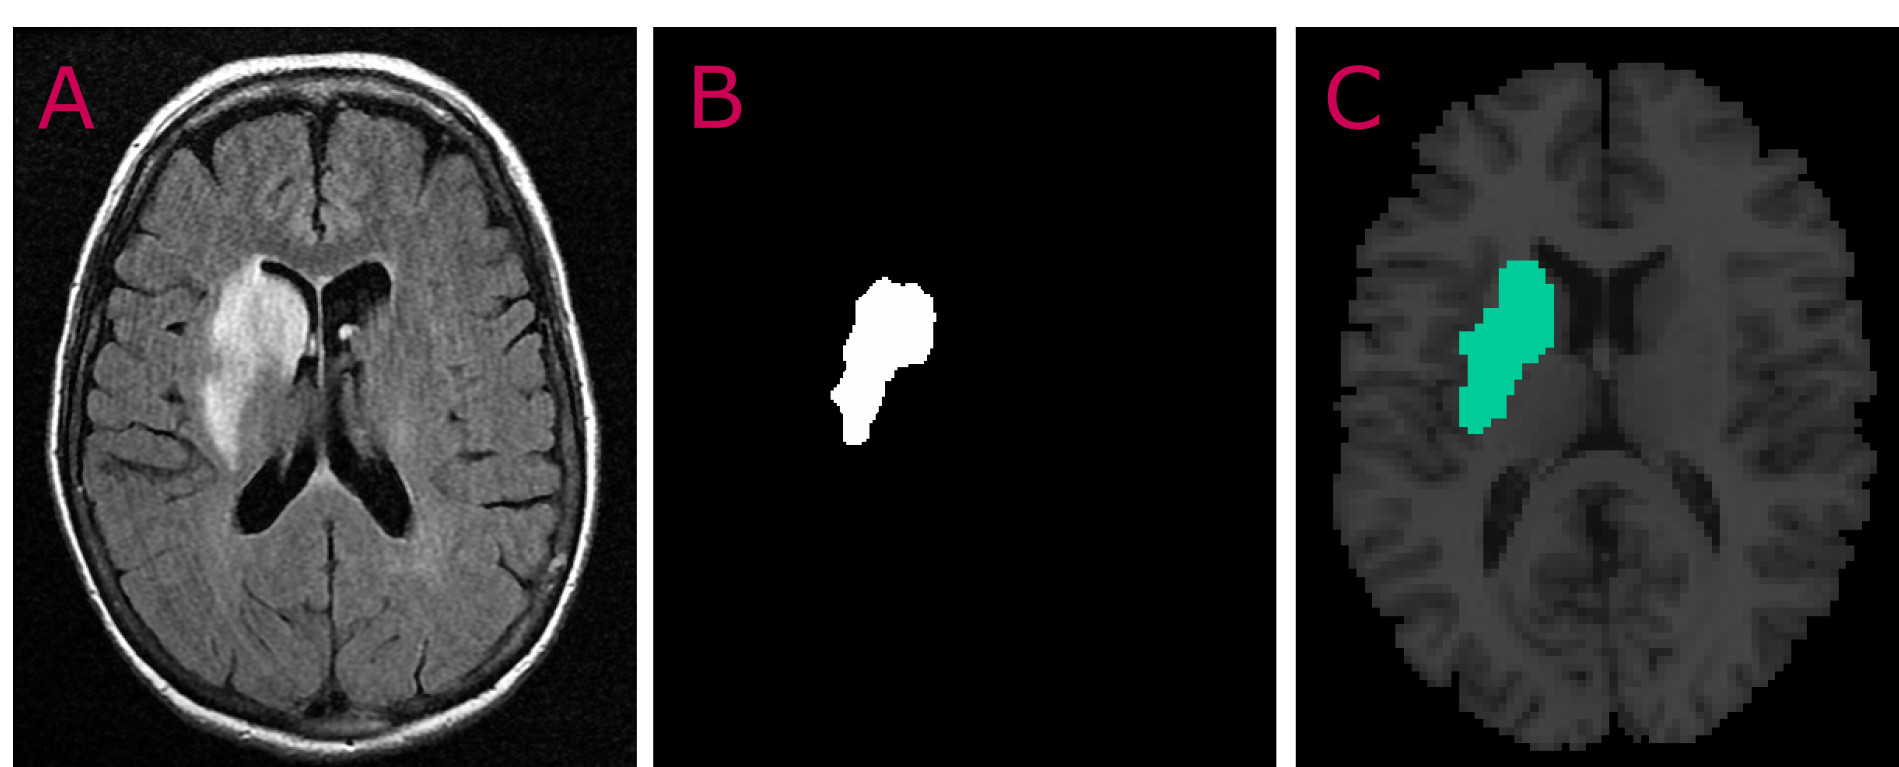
Image processing steps used in creating FI probability maps: A) Raw FLAIR image; B) Binary mask from tracing of A; C) Transformed mask in MNI standardized brain space.
